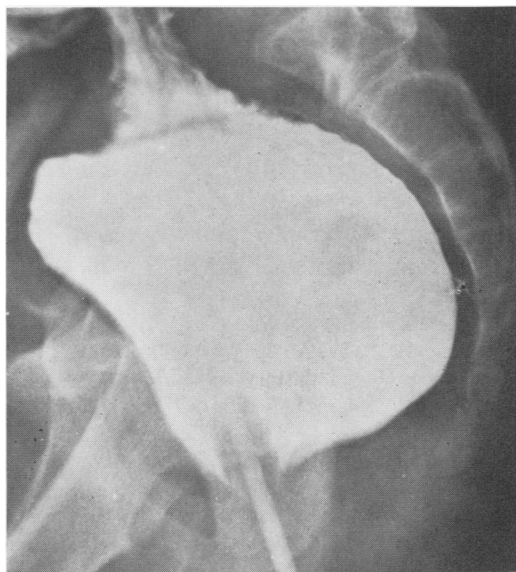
Barium enema x-ray of megarectum without a definite distal narrow segment (Patient 11).
